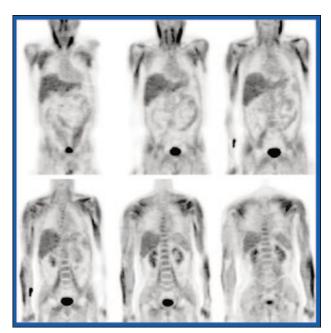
¹⁸F-FDG PET imaging was used to investigate fevers of unknown origin associated with autoimmune diseases. In autoimmune myositis, diffusely increased glucose metabolism was noted in the skeletal musculature of the neck, shoulders, back, pelvis, and arms.
